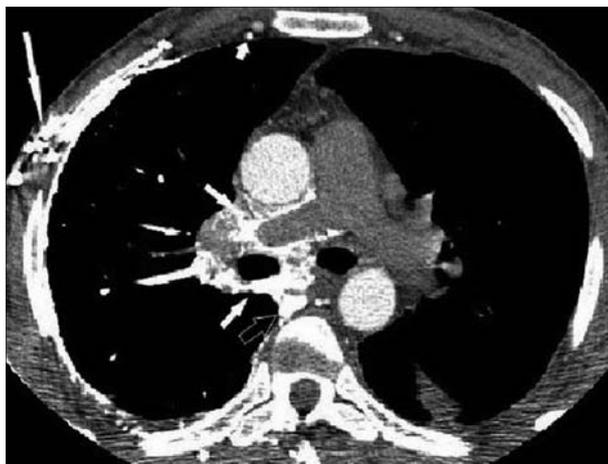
Axial CT image shows early enhancement of the aorta after i.v. contrast injection. Note opacification of the mediastinal venous network (*short arrow*), azygos vein (*open arrow*), dilated chest wall veins (*long arrow*) and right internal thoracic vein (*small arrow*). Also note the absence of superior vena cava opacification.
